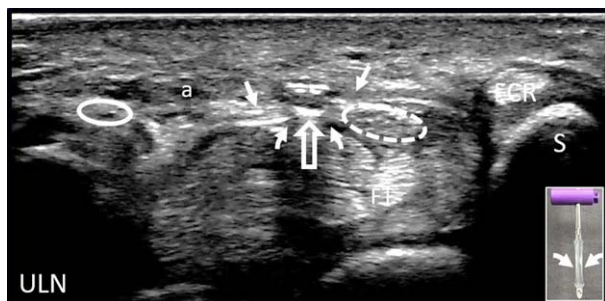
Ultrasound confirmation of complete release of the TCL. Out-of-plane view shows the device (open arrow) with the protective balloons (curved arrows) deflated, showing the device superficial to the transected TCL (solid arrows); a indicates ulnar artery; FCR, flexor carpi radialis; FT, flexor tendons; Rad, radial; S, scaphoid; solid ellipse, ulnar nerve; ThM, thenar muscles; and ULN, ulnar.
